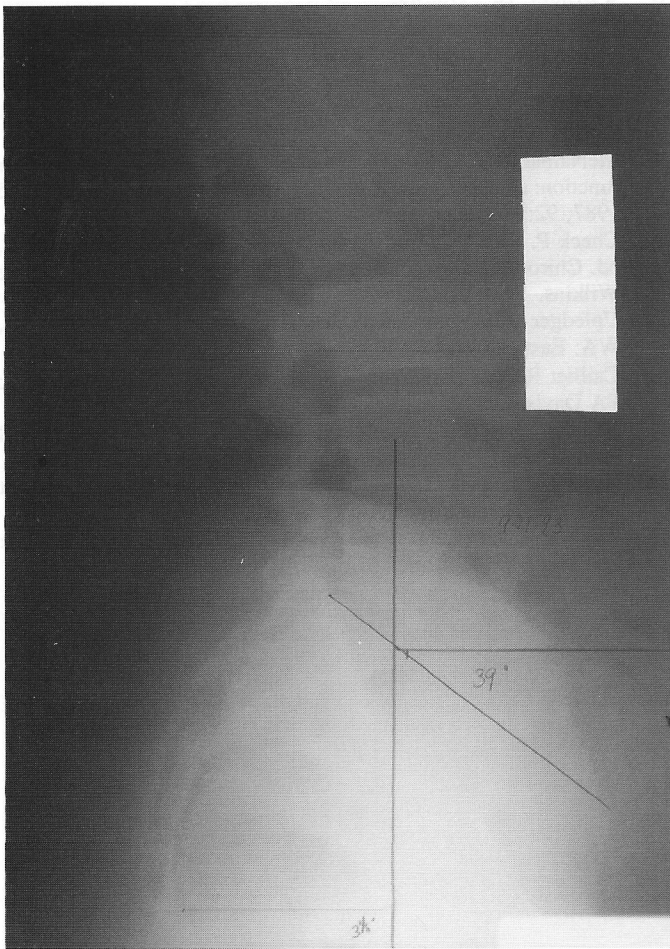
X-ray (September 21, 1993) that shows improvement in sacral displacement.
